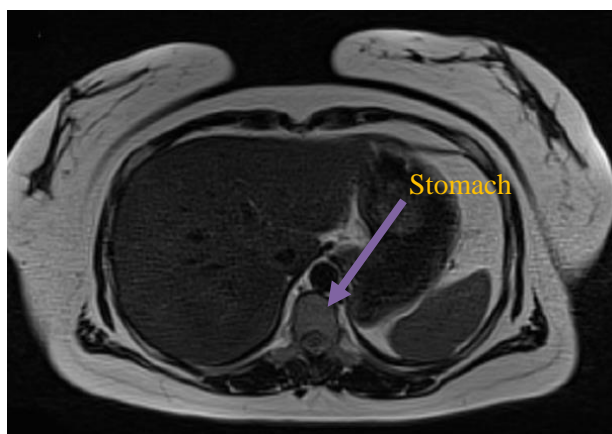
MRI transverse section of abdomen (T2-weighted) under imaging conditions: 2-dimensions, turbo spin echo sequence.
